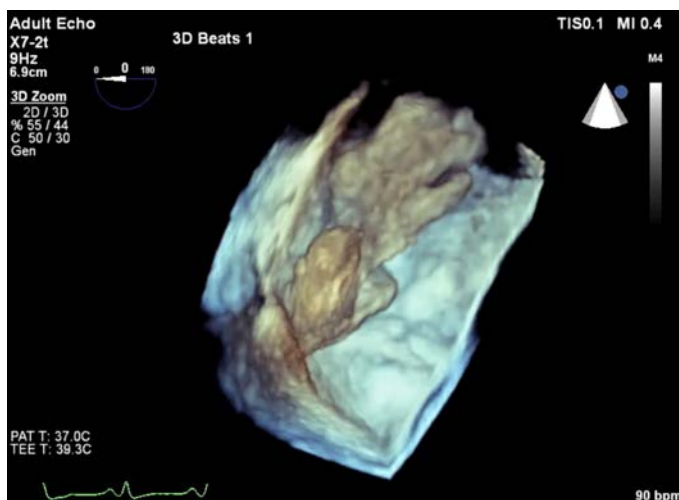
Transesophageal echocardiography revealed a pedunculated giant mass (6 × 2.5 cm) attached to the interatrial septum fossa ovalis region and protruding to the left ventricle in diastole.
